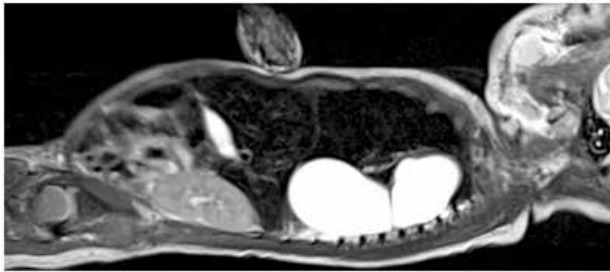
MRI Sagittal view.
